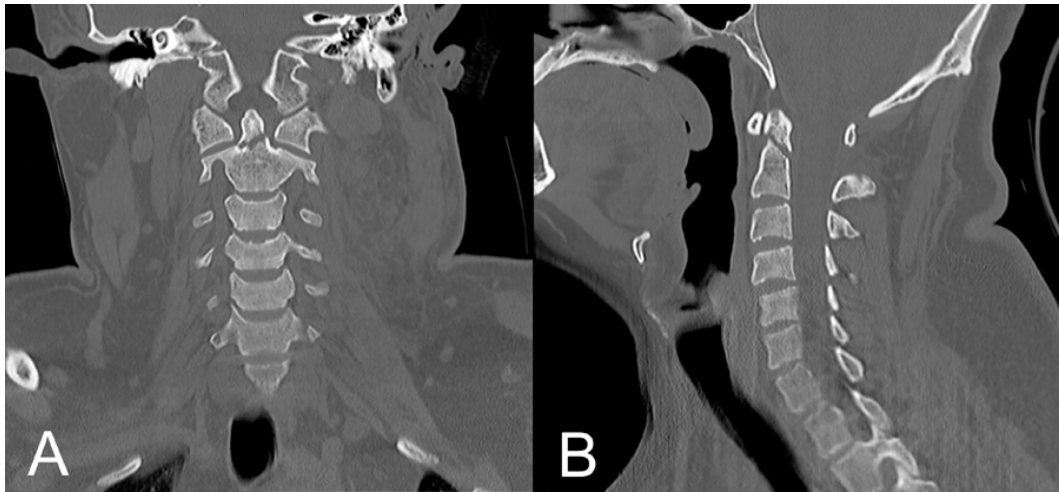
Coronal (A) and sagittal (B) CT images of a patient with an acute type II posterior oblique odontoid fracture. Note the >10 degrees fracture angulation.
